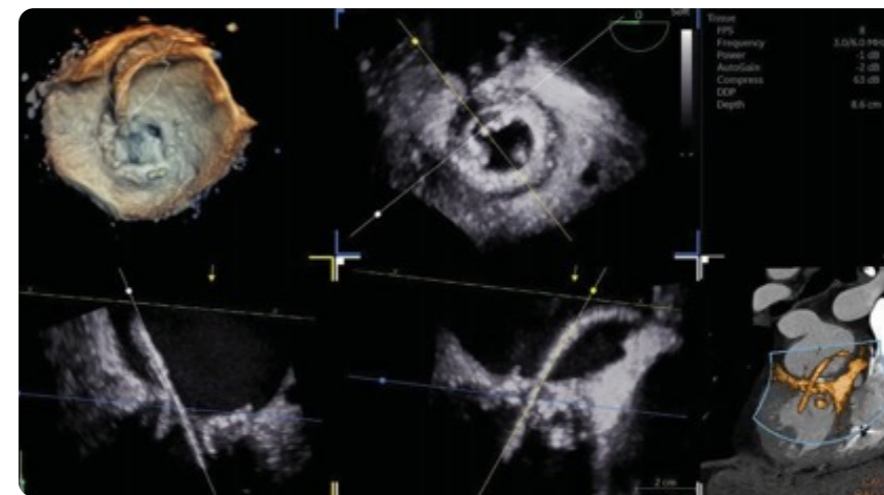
Live co-registered navigation in 4D ultrasound and CT data to better help understand the heart anatomy.
